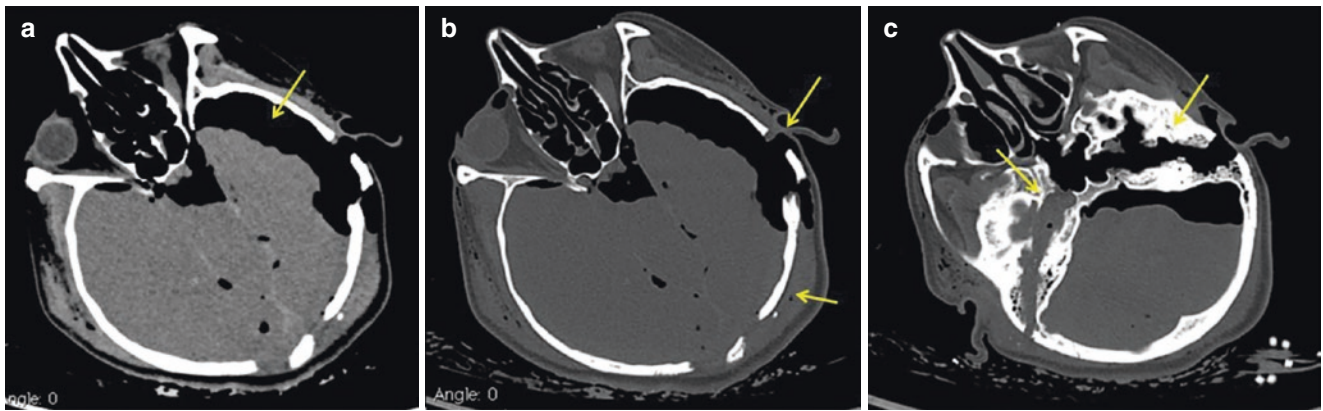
Brain post-mortem CT scans: brain window (a), bone window (b, c). Pneumocephalus associated with subarachnoid hemorrhage (a), depressed fractures of occipital bone (b), frontal sinus (a), ethmoidal
